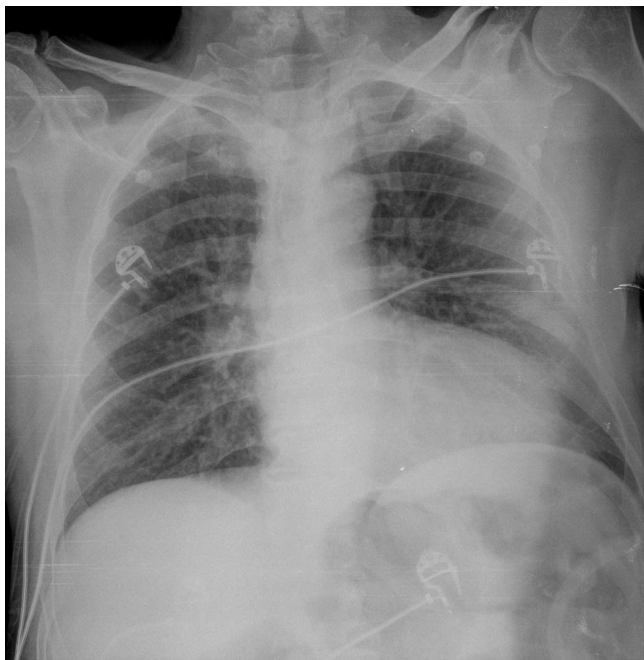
Chest X-ray of the patient in the posteroanterior view, failing to demonstrate the foramen
